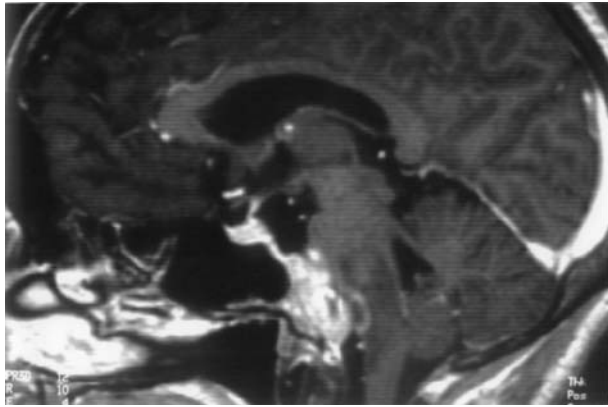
Post Gadolinium T1-weighted MR image obtained at 7 years follow-up. The abnormal signal is still visible inside the brainstem whereas the tumour volume is unchanged
